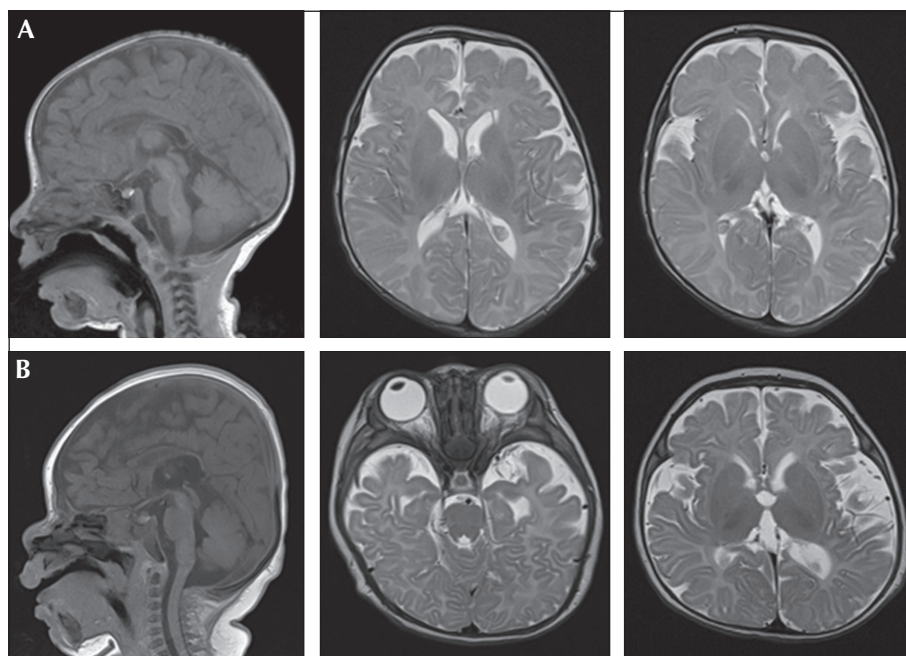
Cranial MRI of the two patients (left: sagittal T1; middle and right: axial T2). (A) The first child at age two months showing hypoplastic corpus callosum, particularly in the anterior portion, wide Sylvian fissure, and small connatal cysts adjacent to the frontal horn of left lateral ventricle. (B) The second child at age two months showing thin corpus callosum, mild ventricular dilatation, and wide CSF spaces, particularly in frontal and temporal regions (indicating reduced cerebral volume) and bilateral posterior polymicrogyria.
